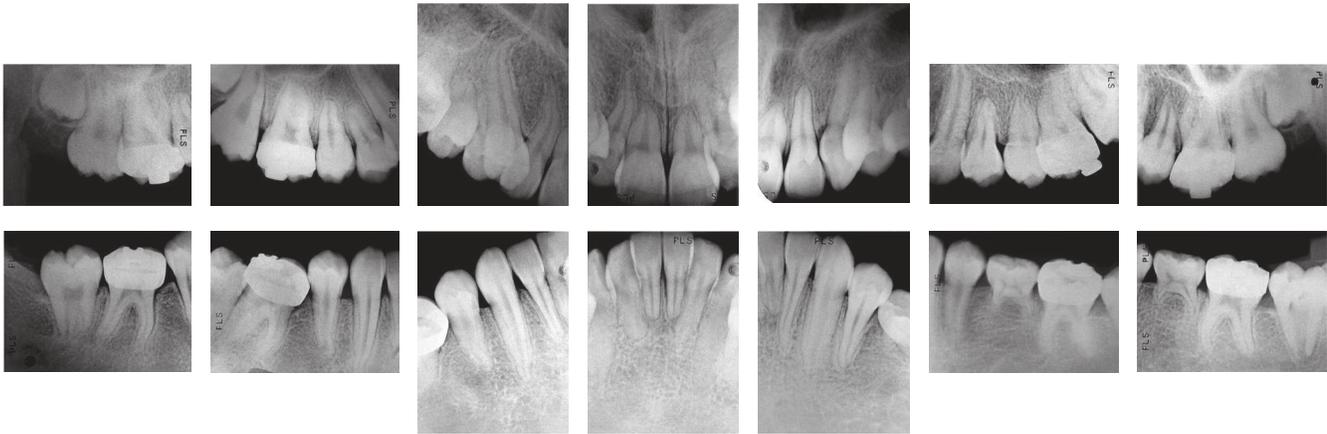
Initial periapical radiographs.
